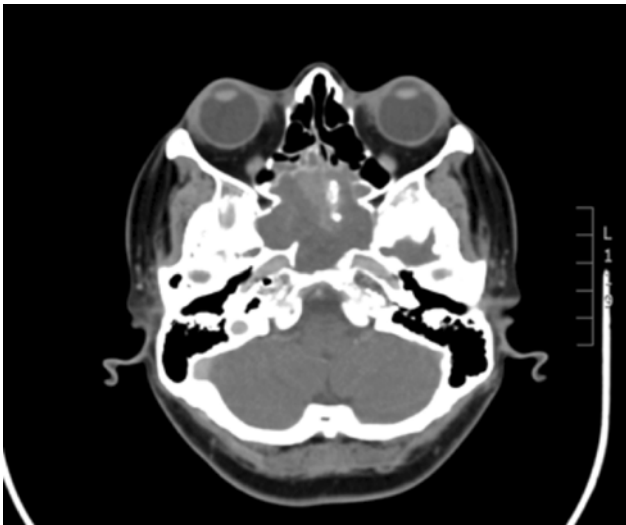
CT scan (with contrast) showing sphenoid sinus lesion with calcification.
